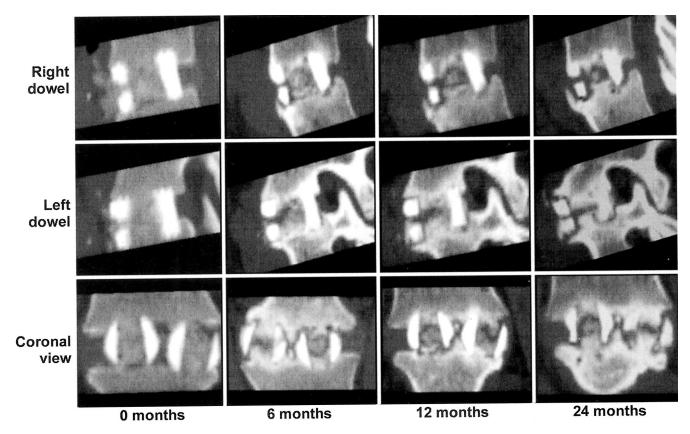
Serial thin-cut CT scans after an L5-S1 fusion using autograft show the development of a pseudarthrosis. At six months, the grafts within the dowels and the dowels themselves appear to have become attached to the adjacent vertebral end plates. At 12 months, lucencies appear separating the dowels from the vertebral end plates. By 24 months, a radiolucent line involving the inferior portion of both dowels highlights noncontiguous bone formation between the vertebrae consistent with a pseudarthrosis.
